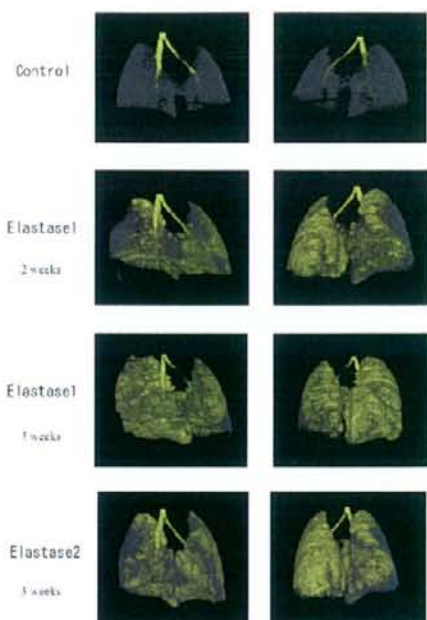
Three-Dimensional Reconstructions of CT
